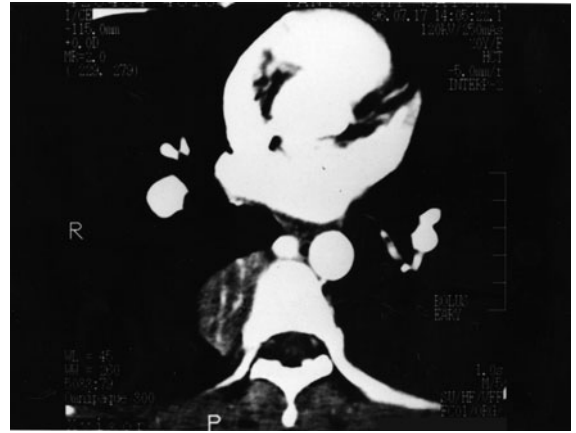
Computed tomography of the chest reveals a mediastinal mass next to the right side of T6 with a reticular structure and a stalk that shows enhancement
